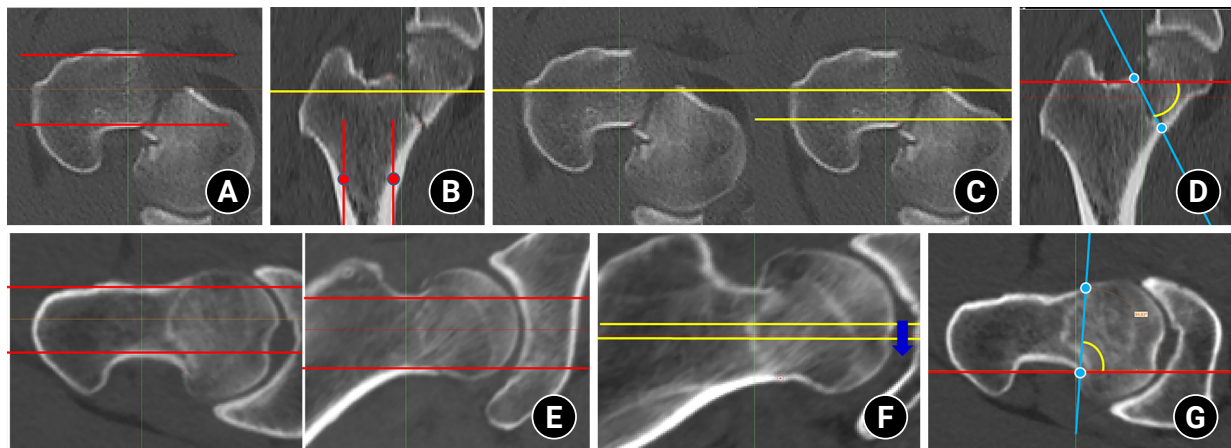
To make consistent measurements and eliminate projection error, after the computed tomography scan plane was reformatted to an axial plane parallel to the femoral neck axis, red lines were placed anterior and posterior to the neck cortex in the axial (A) and coronal (B) planes. The yellow lines were placed in the centerline and posterior cortex (C). Then, (D) the coronal Pauwels angle (PA) was measured between the red line (ground line) and the blue line (reformatted fracture angle) in three consecutive images of the coronal plane. (E) The red line marked the anterior and posterior cortex in the axial and coronal planes. (F) The yellow lines were placed along the centerline of the neck, and three consecutive images of the axial plane were chosen. Then, (G) The axial PA was measured between the red line (ground line) and the blue line (reformatted fracture angle).
